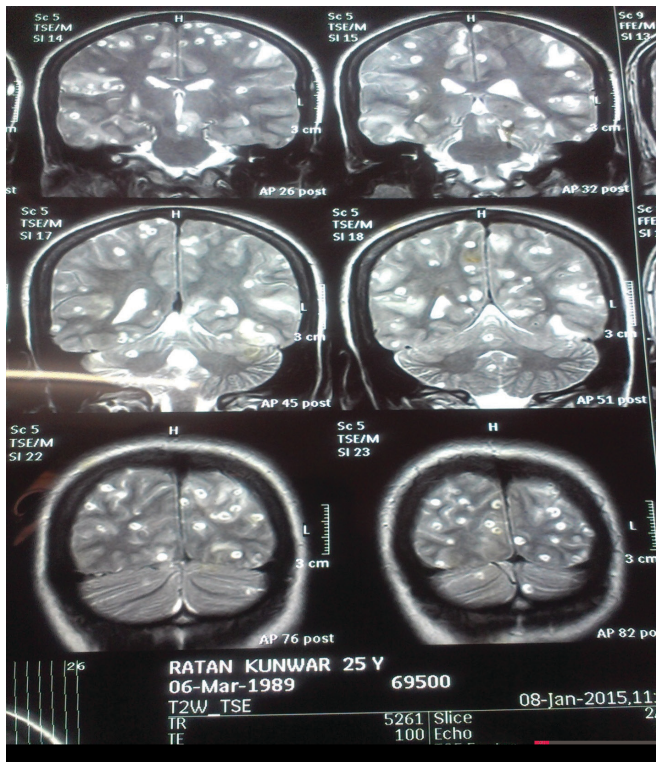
MRI Brain suggestive of disseminated numerous subcentimeter sizes cystic lesions in bilateral cerebral hemisphere, cerebellar hemisphere, basal ganglia and midbrain with eccentric scolex suggestive of Neurocysticercosis.
